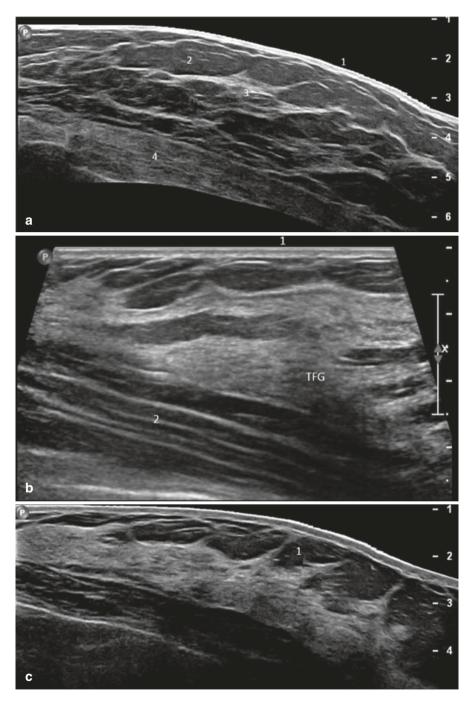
Ultrasonographic anatomy of the breast. (a) 1. Skin. 2. Subcutaneous adipose tissue. 3. Fibroglandular tissue. 4. Pectoral muscle. (b) Visual field of the breast should include from the skin (1) to the pectoralis muscle (2). TFG: Fibroglandular tissue. (c) Cooper ligaments
